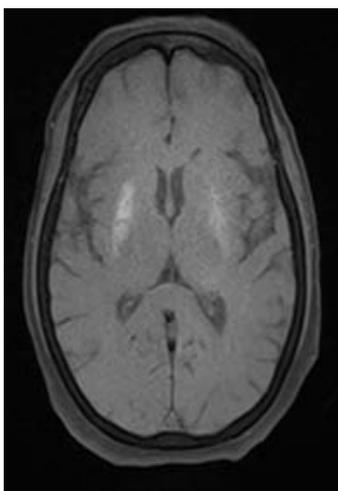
MRI Brain in T1 weighted image shows Bilateral hyperintensities in putamen & caudate nucleus
